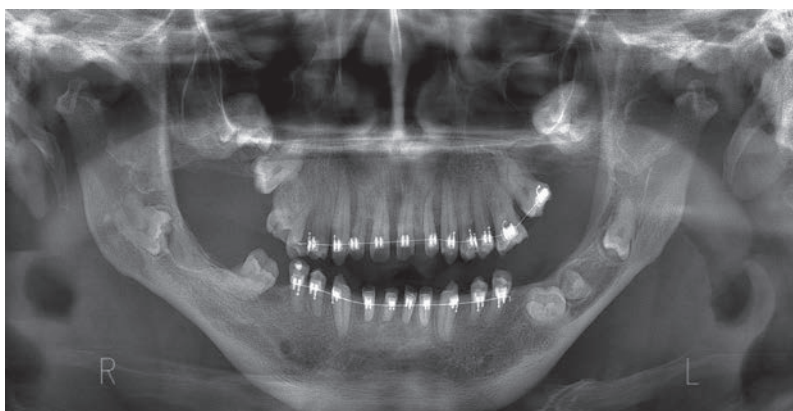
Panoramic radiograph after 20 years from the first visit showing retained teeth, absence of recurrent cystic lesions and orthodontic treatment in progress.
